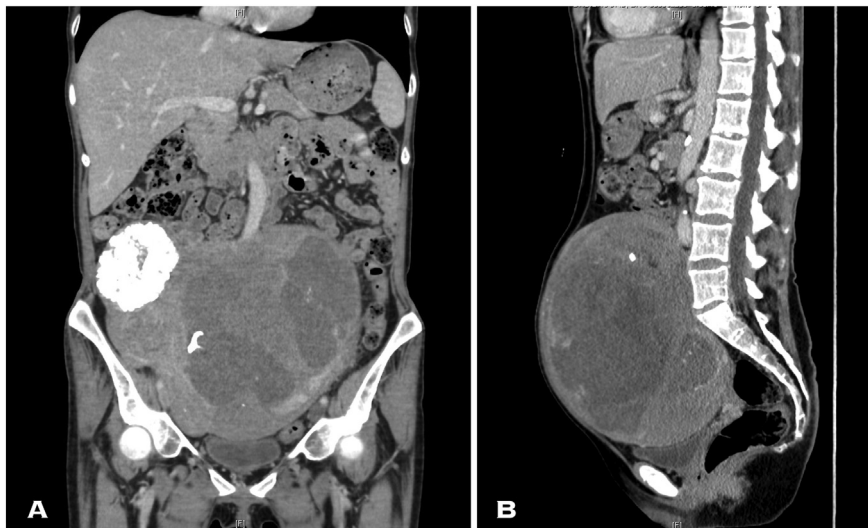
Abdominal and pelvis computed tomography (CT) images. A) Coronal and B) sagittal views demonstrating a heterogeneous and septated mixed density pelvic mass with an area of calcification in the right lateral aspect.
